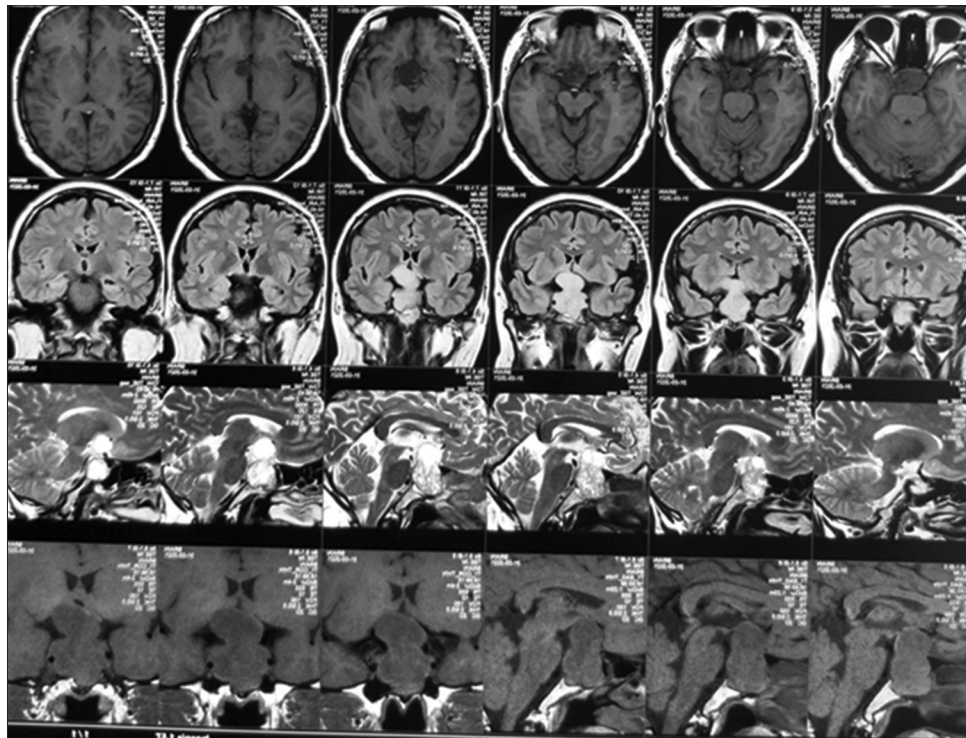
Magnetic resonance imaging of the patient with pituitary adenoma
